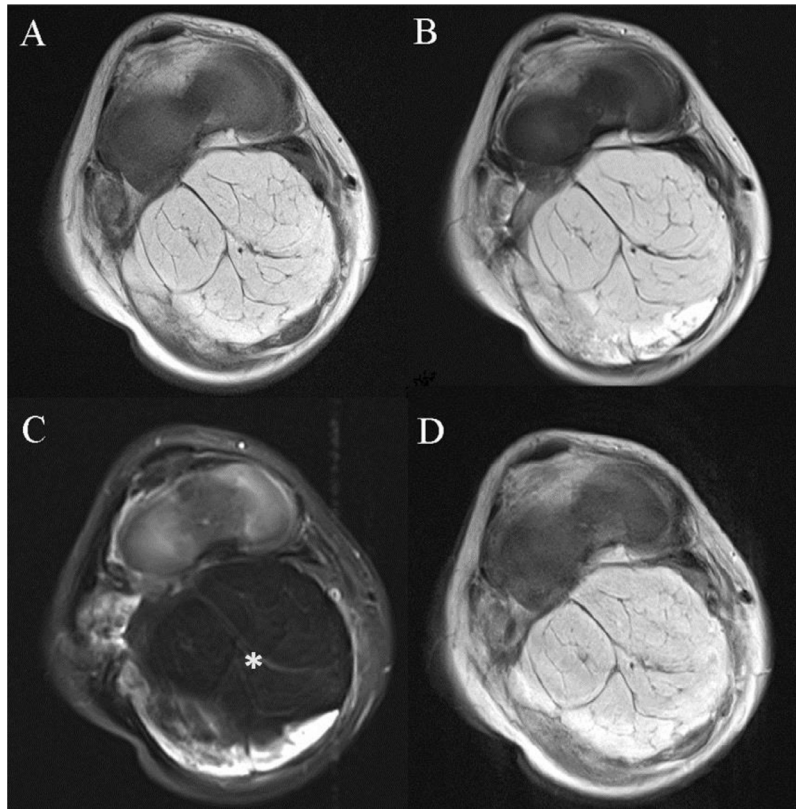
The presence of fat component was shown by the hypointense signal on fat-suppressed T2-weighted image (asterisk). (A) T1-weighted, (B) T2-weighted, (C) Fat suppressed T2-weighted, and (D) Contrast-enhanced T1-weighted images of the MRI.
